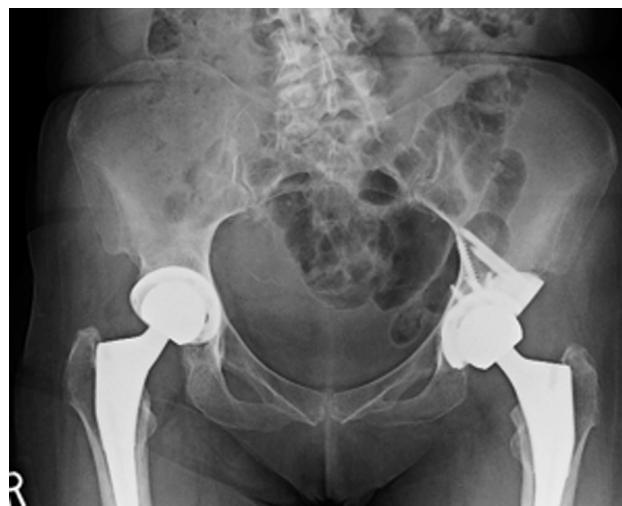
Anteroposterior pelvis radiograph of case 3 at 12 months demonstrating osteointegration of the cup and augment.
